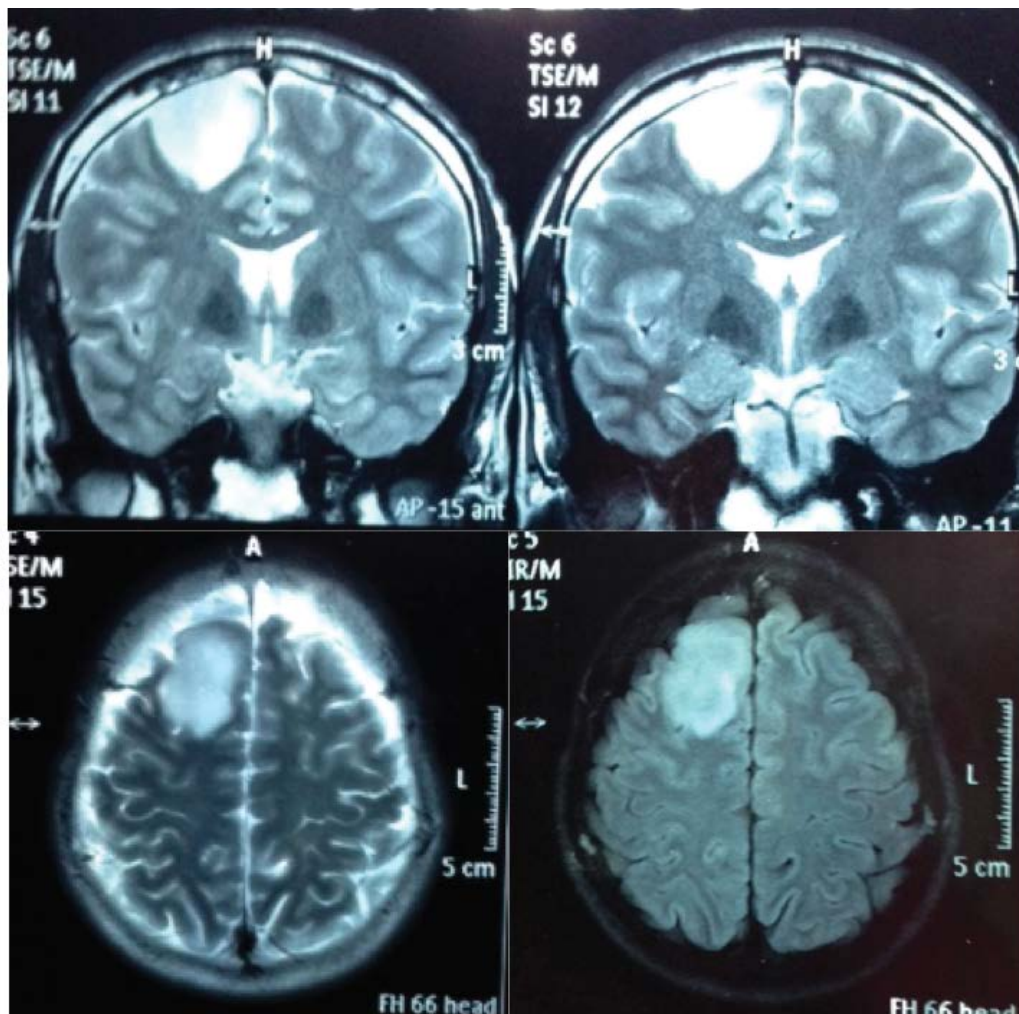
Simple Brain CT scan. A large-extension Glioma-like tumor lesion in the motor area with a low degree of malignancy.
